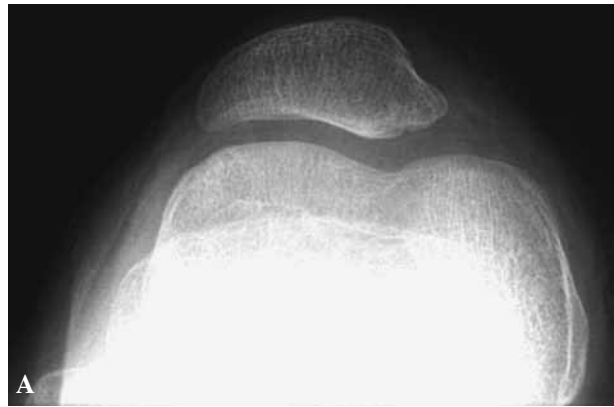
A-C. — Preoperative patella sunrise view (A), preoperative axial CT image (B), and postoperative patella sunrise view (C) at the last follow-up of case no. 1. The last radiograph shows the congruency of the patellofemoral joint.
